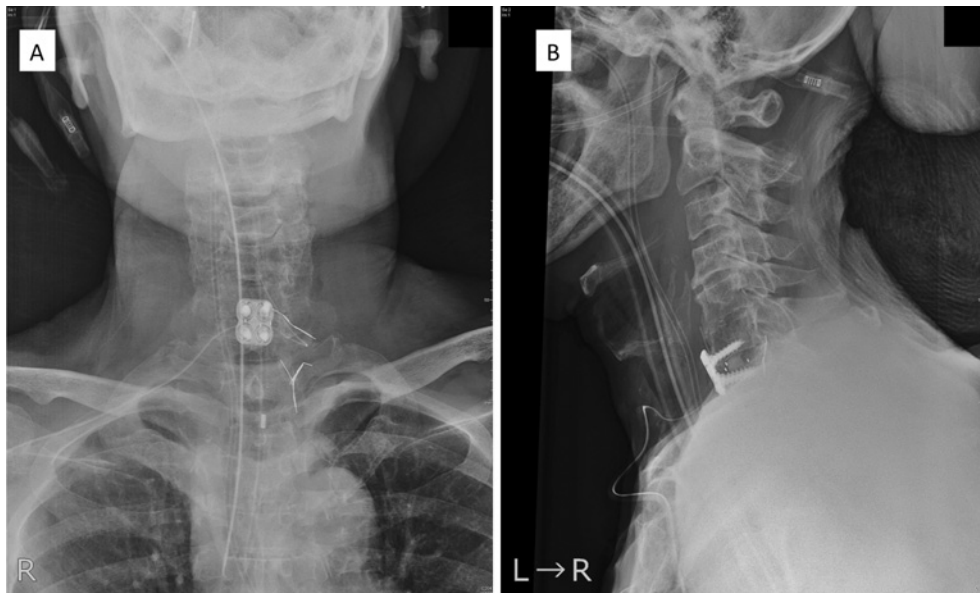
Postoperative X-ray images of C6/7 anterior discectomy and fusion. A: Anteroposterior X-ray and B: Lateral X-ray.
